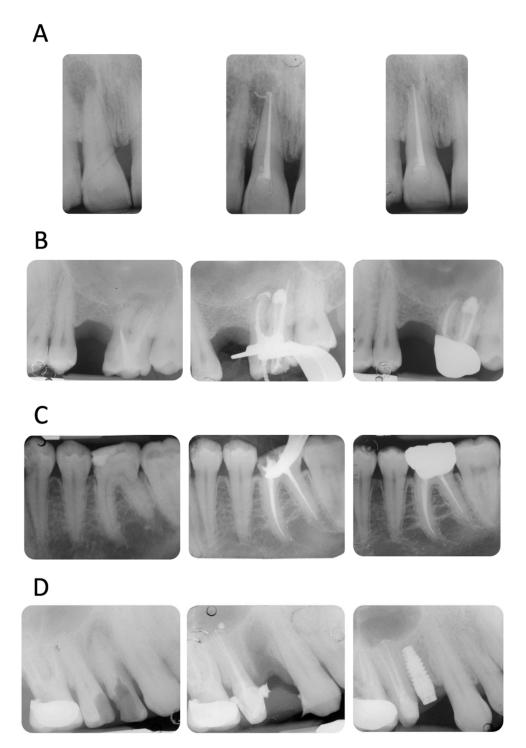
(A) Upper incisor with a periapical lesion (PAI = 5). The periapical X-ray at 12 months showed resolution of the periapical pathology (PAI = 2). Note the disappearance of sealer extrusion. (B) Upper molar with previous failed root canal treatment (PAI = 4). The mesio-buccal root revealed a periapical lesion, a metal post, and an incomplete filling of the apical third. It is interesting to observe the sealer morphology after root canal obturation and after 12 months of follow-up. The extrusion around the mesio-buccal root seems to have disappeared, while the one in the palatal root is still present. No post-operative pain was reported (VAS = 0 throughout the entire treatment and follow-up). (C) Lower first molar with a deep carious lesion. Slight periapical extrusion was observed in the mesial and distal canals. Uneventful healing was observed at the 12-month follow-up. (D) Upper second premolar with a deep carious lesion and no periapical radiolucencies (PAI = 2). Slight modification of the sealer extrusion was observed at the 12-month recall.
